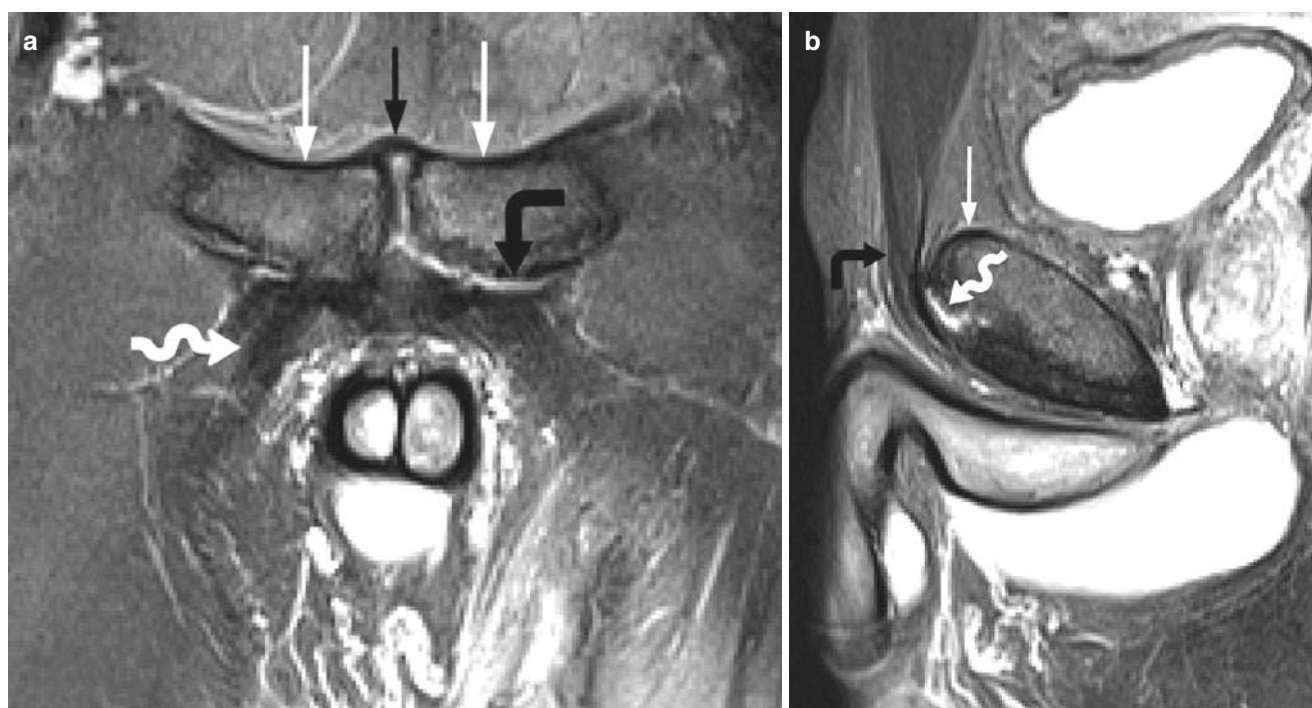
Partial tear of adductor longus and pre-pubic aponeurosis (P-PAC) in 34-year-old hockey player with athletic pubalgia. (a) Coronal fat-suppressed T2-weighted MR image demonstrates the superior pubic ligament (*straight black arrow*), pubic bones (*straight white arrows*), and right adductor longus tendon (*wavy white arrow*). At osseous attachment
